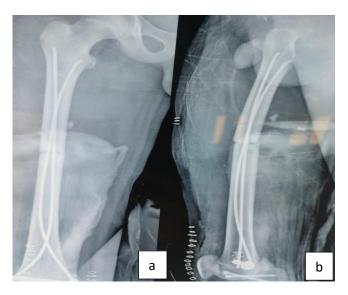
(a and b): Post-operative Antero-posterior and lateral X-ray views of right thigh showing diaphyseal fracture of right femur fixed with closed reduction and TENS.
